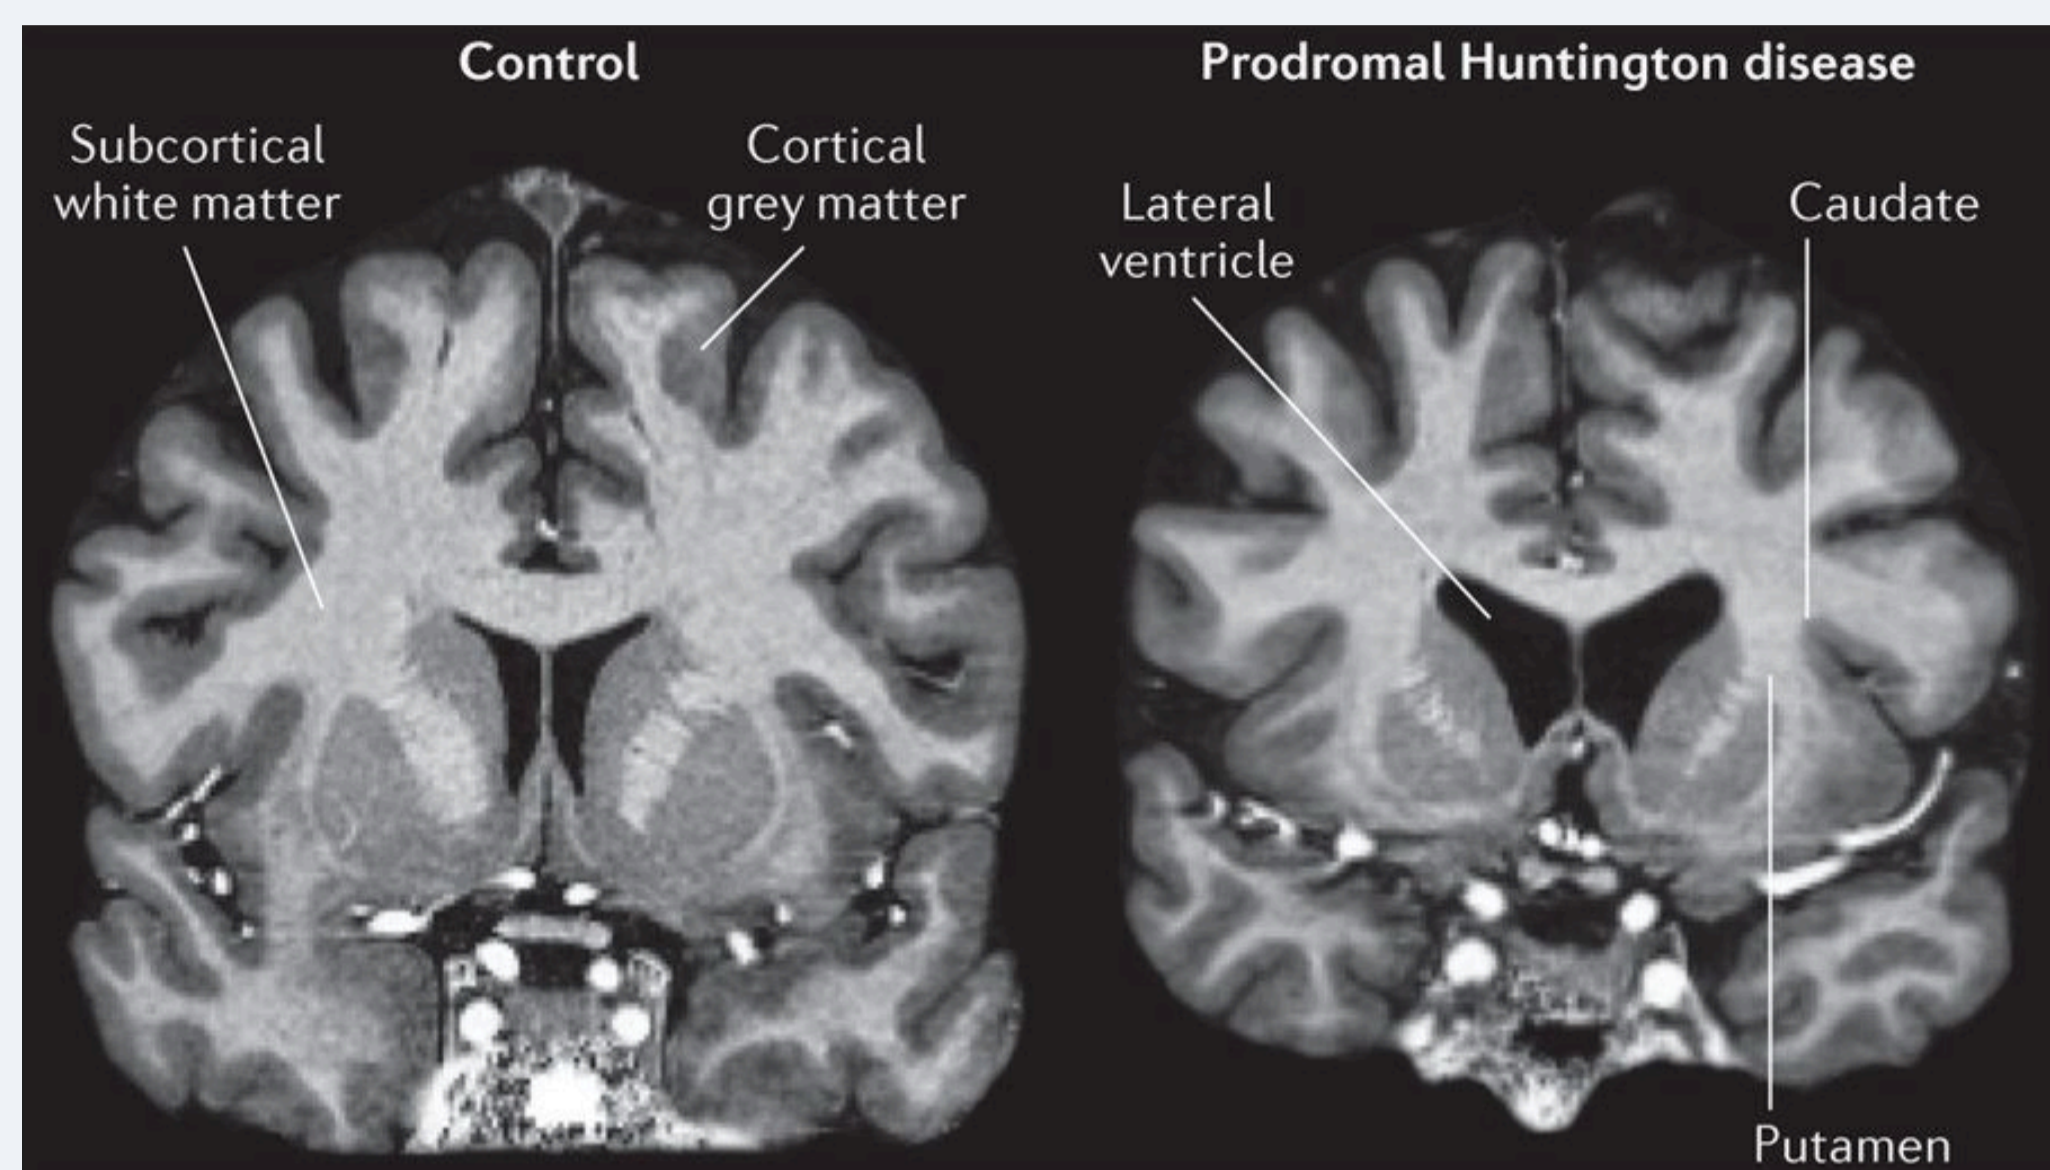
Brain atrophy in prodrional Huntington's Disease shown using 7T MRI – Bates et al (2015)
